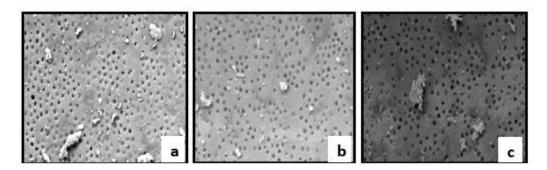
Group B– Maleic acid 7% with ultrasonic agitation a) Coronal third; b) Middle third; c) Apical third
